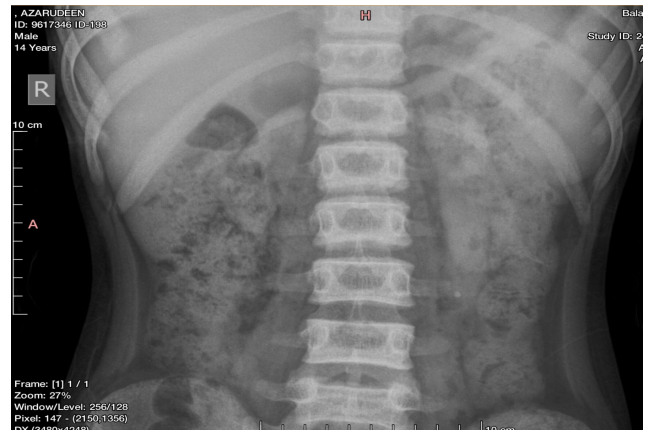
Bilateral increased renal density seen in the radiograph
